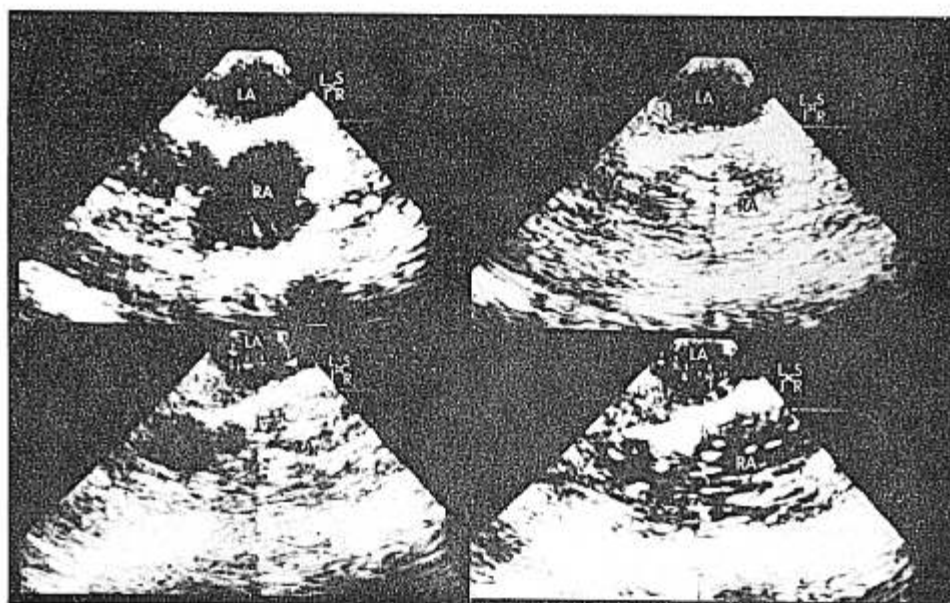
Paradoxical air as noted by transesophageal echocardiography. Upper left: normal; upper right: air in right atrium; lower left: air in left atrium, right atrium nearly opacified; lower right: more air in left and right atrium.
